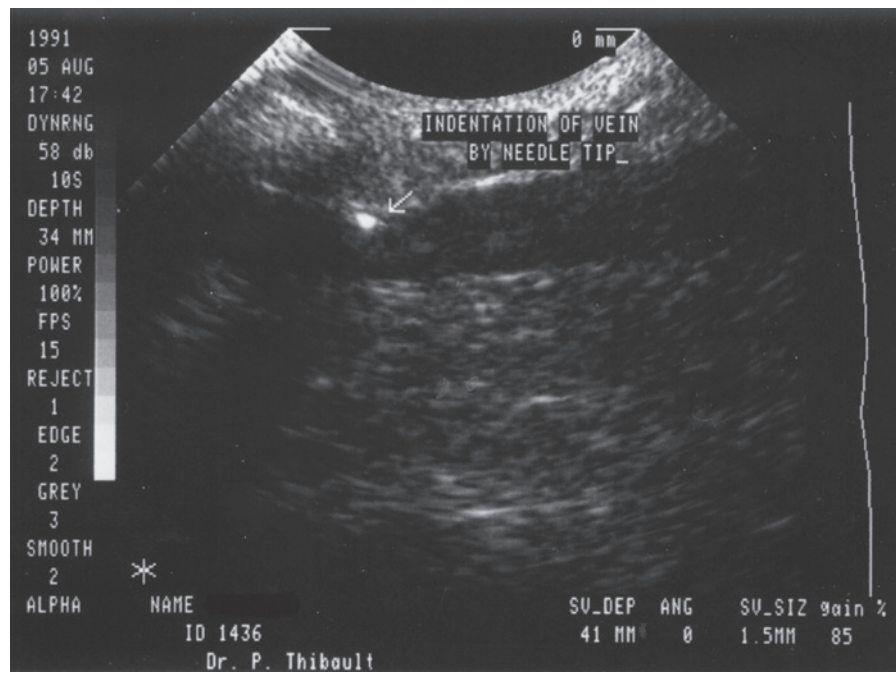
B-mode ultrasound image of reflective needle tip indenting vein wall immediately prior to vein puncture. (From Thibault PK, Lewis WA. *J Dermatol Surg Oncol.* 1992. 18: 895–900.)
